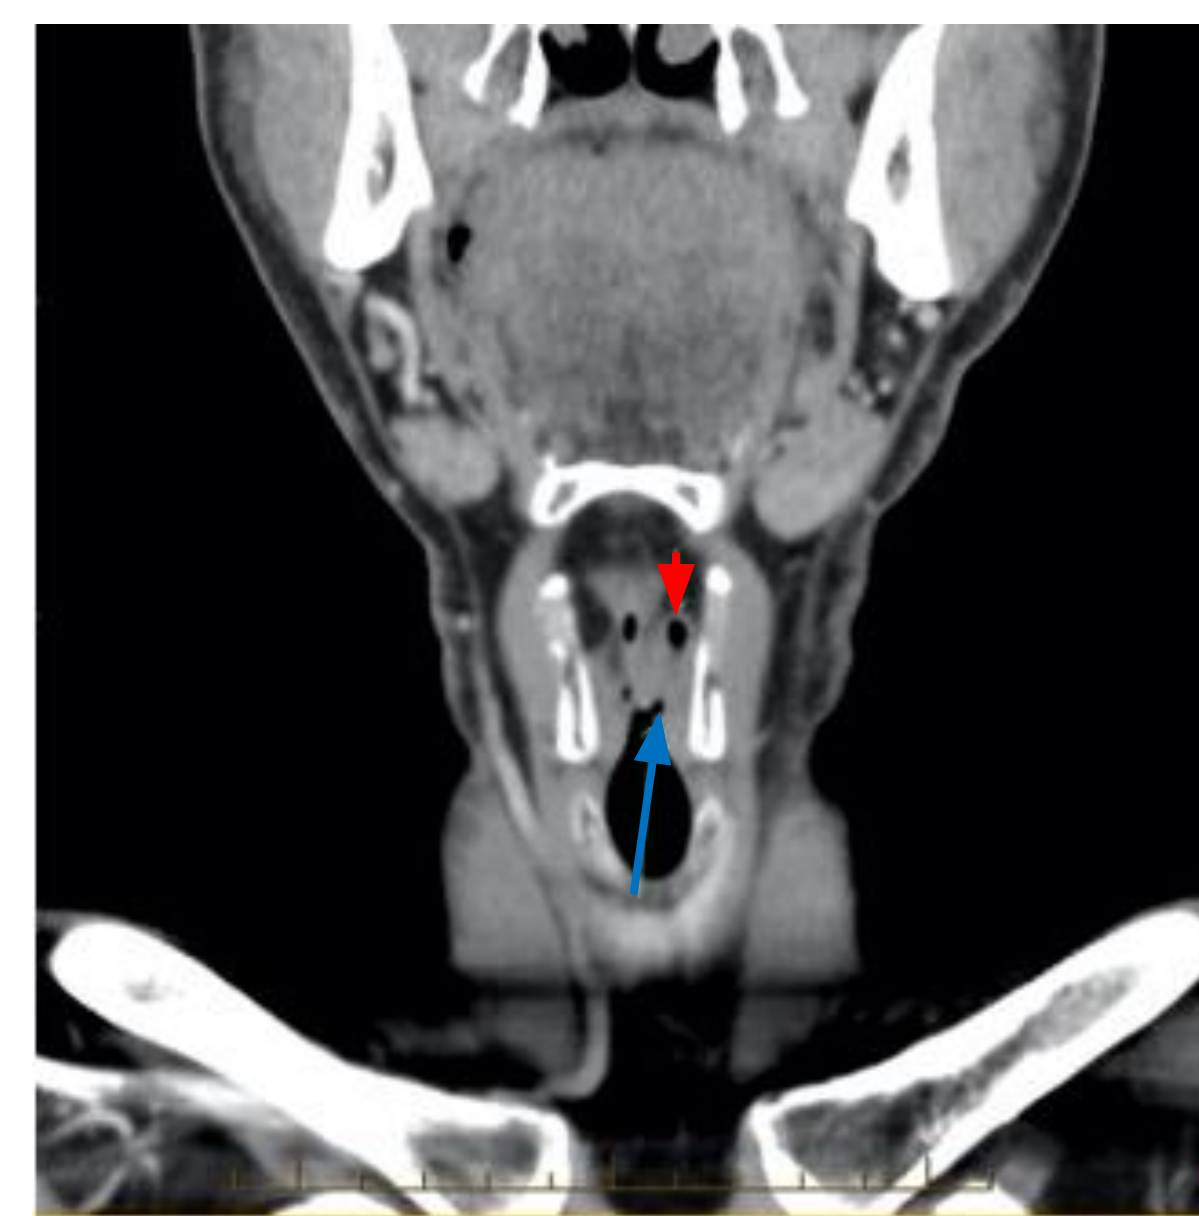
CT scan with contrast in the coronal plane demonstrating a left-sided internal laryngocele (red arrow), with communication with the laryngeal lumen (blue arrow).
